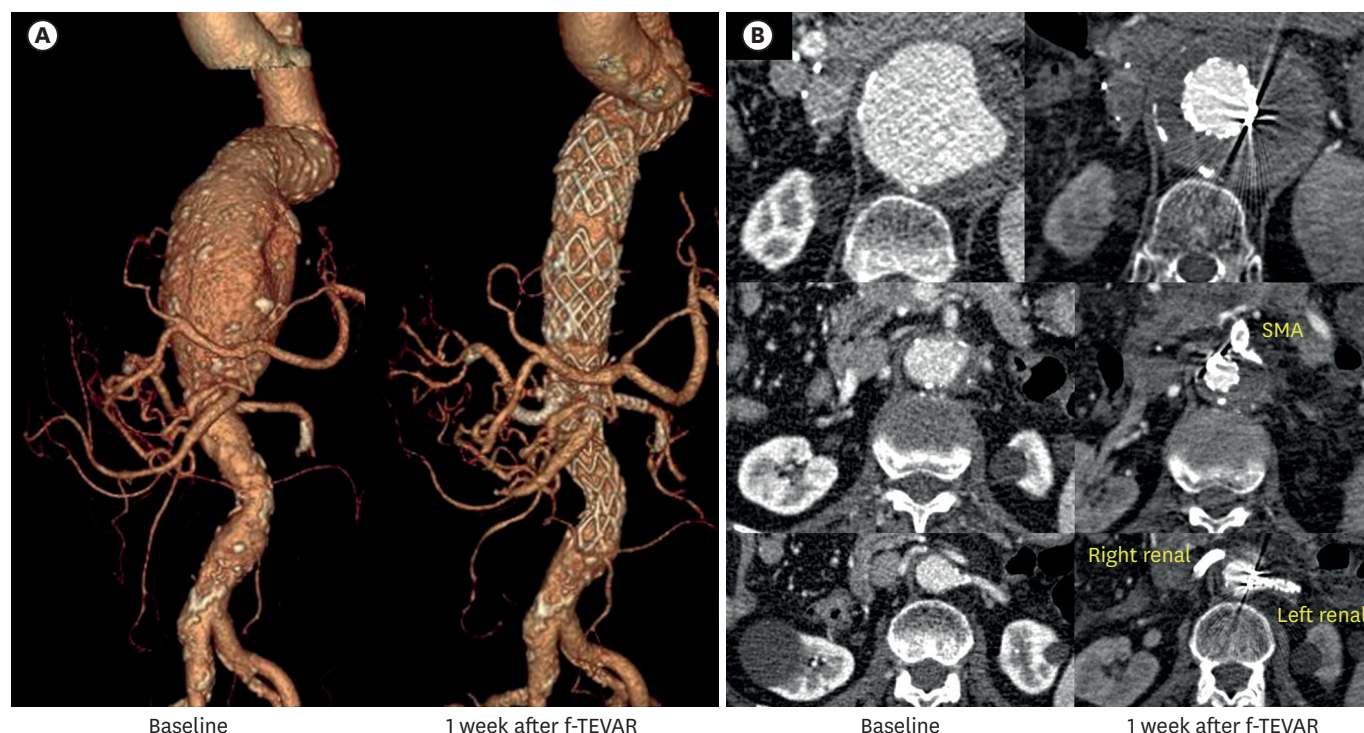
Comparison of pre- and post-procedural CT. (A) Volume-rendered 3-dimensional reconstructions before and after the procedure, demonstrating accurate alignment of the fenestrated stent graft to the visceral arteries. (B) Axial CT images demonstrating maintained patency of all bridging stent grafts to the SMA and both renal arteries, with no evidence of endoleak. CT = computed tomography; f-TEVAR = fenestrated thoracic endovascular aneurysm repair; SMA = superior mesenteric artery.
